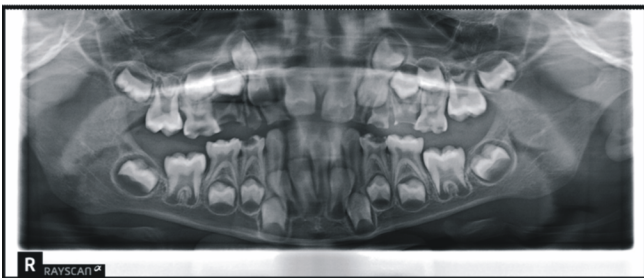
Oral Pantomogram radiograph of the patient
